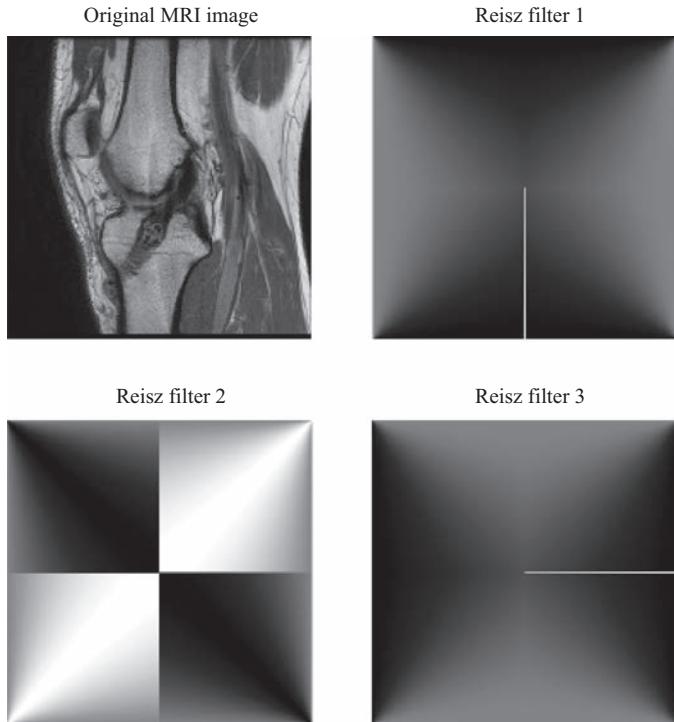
Original MRI image and different Riesz filters
